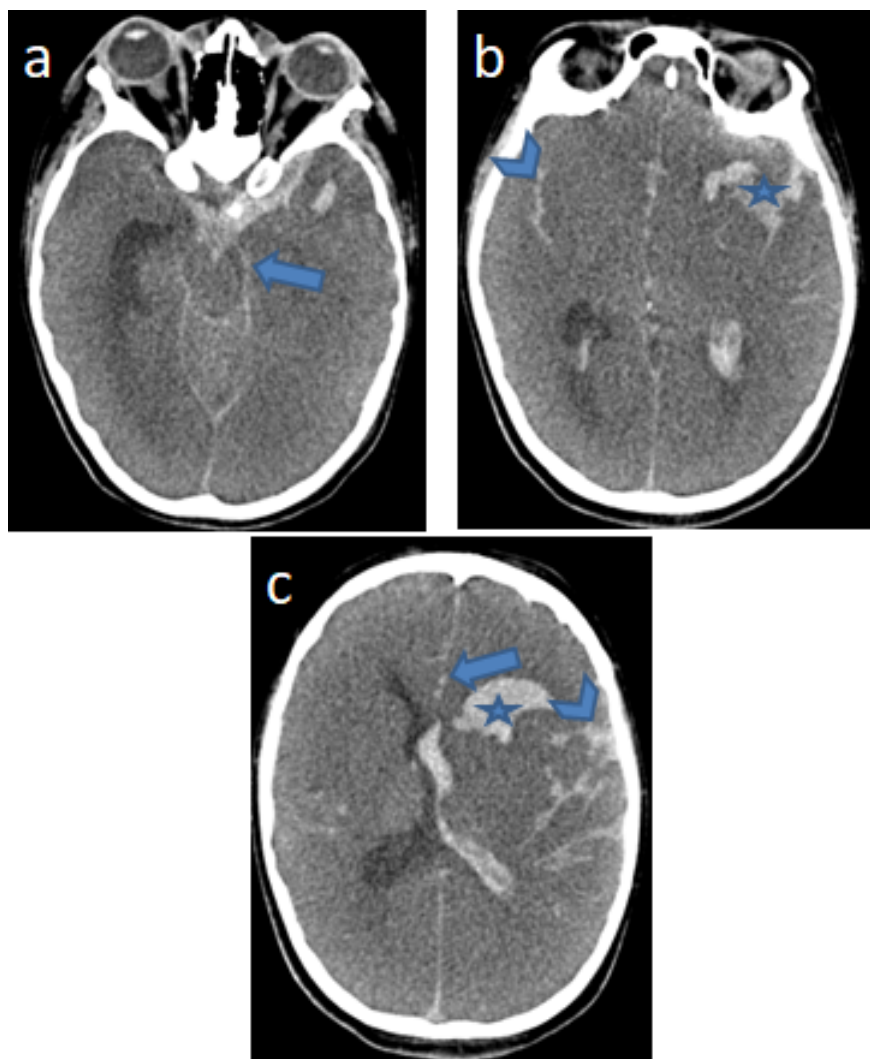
cerebral CT scan showing : left frontotemporal hematoma (star) with quadri ventricular and sub arachnoidal hemorrhage (arrow head, b,c) with subfalcine (arrow, c), homolateral uncal transtentorial (arrow, a) cerebral herniations
